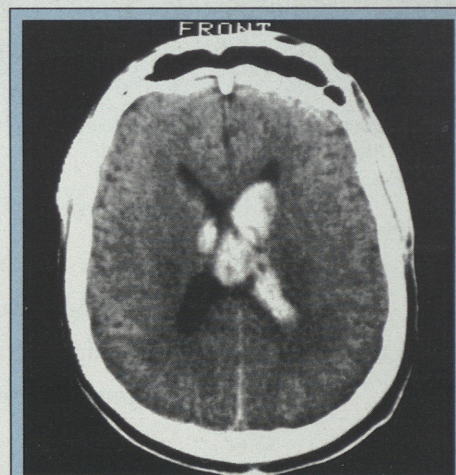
Noncontrast axial CT showing intraventricular haemorrhage in lateral ventricles.
